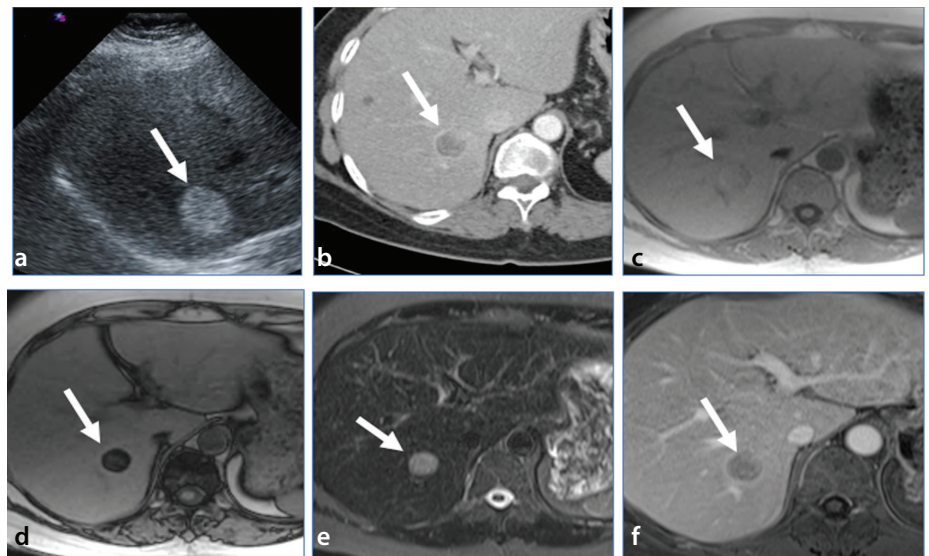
Angiomyolipoma. Transabdominal ultrasonography (a) shows a round echogenic mass (white arrow). Axial contrast-enhanced CT (b) shows a round, peripherally enhancing mass with poor central enhancement. Axial T1-weighted in-phase (c) and opposed-phase (d), axial T2-weighted (e), and post-gadolinium T1-weighted magnetic resonance images with fat suppression (f) show a round liver mass demonstrating loss of signal on opposed-phase images, high signal intensity on T2-weighted images, and rim enhancement following contrast administration.
